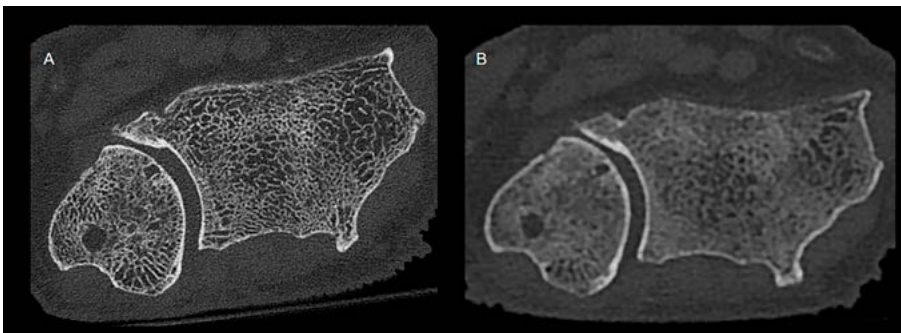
Axial images of the DRUJ obtained from a (a) clinically used photon-counting detector CT protocol with a spatial resolution of 0.2 mm with half of the dose compared with the EID-CT image in a state-of-the-art EID-CT protocol (b), with a maximum spatial resolution of 0.3-0.4 mm acquired at a clinically used CT DI of 12 mGy. DRUJ: distal radio-ulnar joint; CT: computer tomography; EID: energy-integrating detector.
